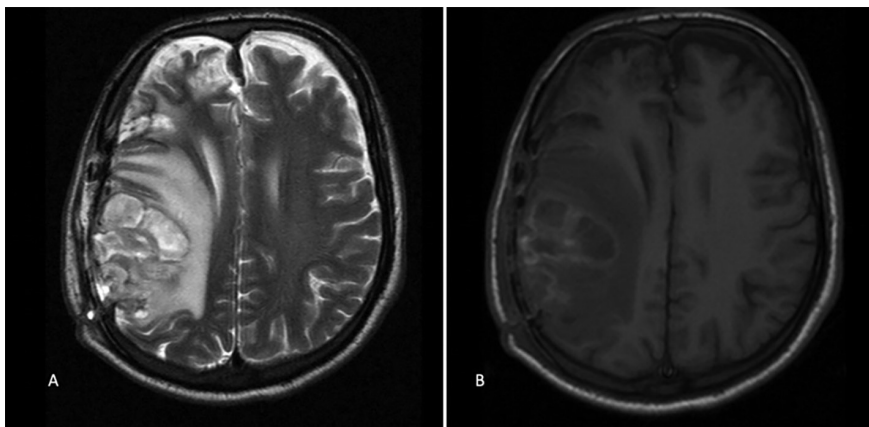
MR images of the patient before surgery: A and B) T2 sequence axial image demonstrating multilobular hemispheric edema and shifted abscess.
